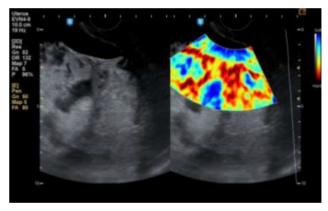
A case in which sonography suggested placental invasion (left image) and elastography showed tissue hardness demonstrated by the red color (right image) with confirmed intraoperative placental invasion
